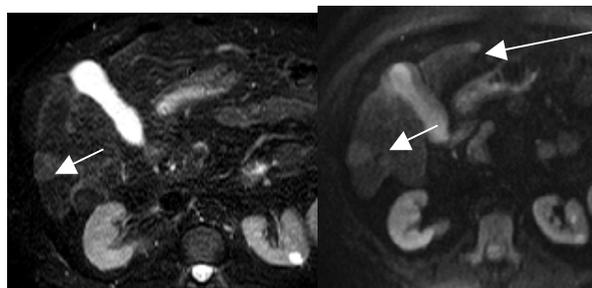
T2WI and DWI (b50) both show a lesion in segment 6 of this cirrhotic liver (short arrow), but an additional lesion in segment 3 is seen only on DWI (long arrow).
